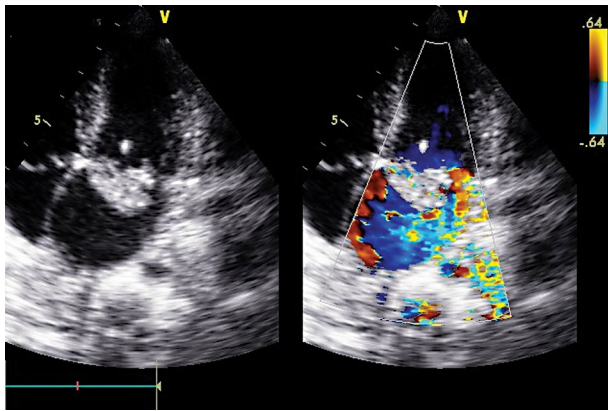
Diagnostic transthoracic echocardiography showing massive mitral valve insufficiency with the presence of fixed vegetations over posterior and anterior leaflets, disrupted anterior chordae
